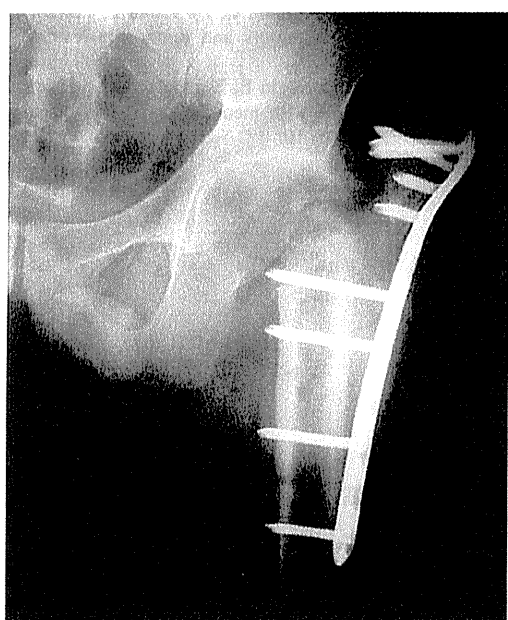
Plain radiograph (A-P view) 3 years after revision surgery. The femoral head was resected, and the greater trochanter was united
